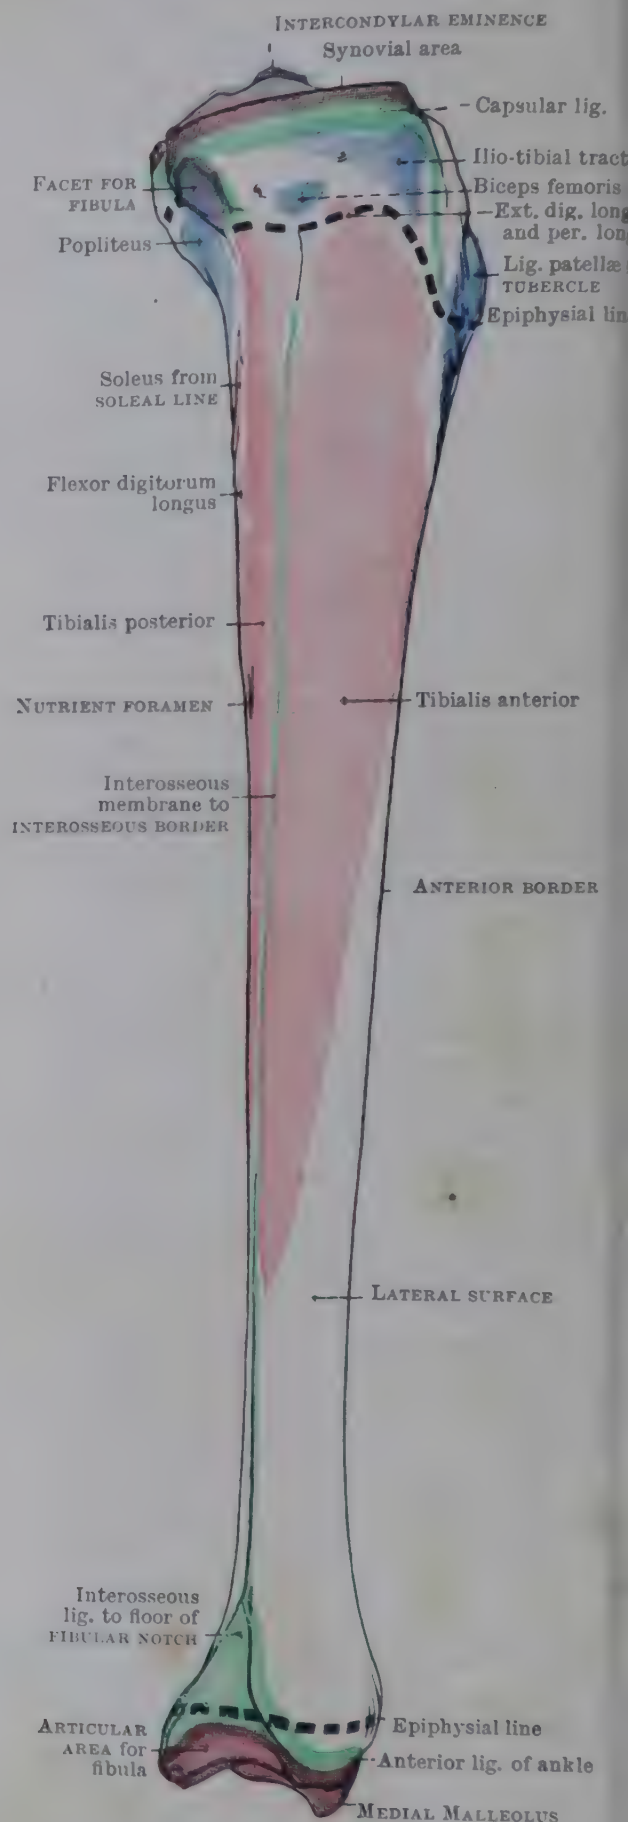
LATERAL ASPECT OF RIGHT TIBIA.
